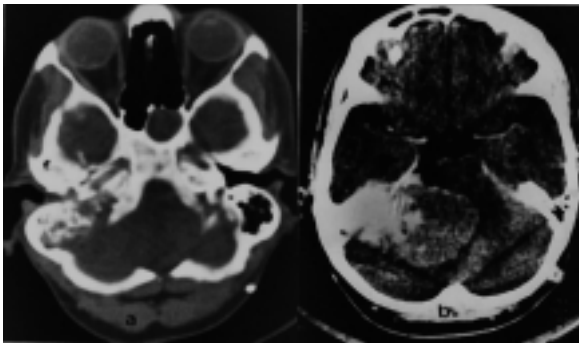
(a) Preoperative CT scan section (bone window settings) showing the lytic lesion involving the mastoid and petrous portions of the temporal bone with a moth eaten appearance (b) Preoperative contrast CT scan section showing the dense enhancing component of the tumor centred on the petrous temporal bone, and a relatively non-enhancing component extending across the midline.
